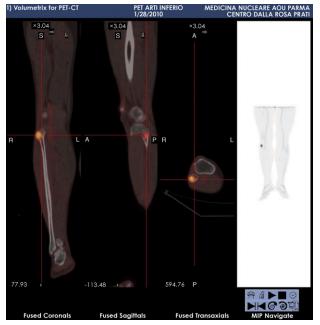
Positron emission tomography/computed tomography showing enhanced F-18 fluorodeoxy-D-glucose uptake at the level of the proximal end of the right fibula.
